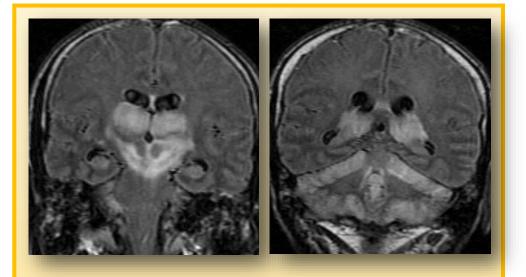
Two coronal FLAIR images from the same patient as figure 1 showing bilateral symmetric high signal/edema and parenchyma swelling in the thalami, within the upper brainstem and within the upper and lower cerebellar cortex. As is usually the case the edema is much more visible on the FLAIR sequence when compared to the T2 acquisition.
